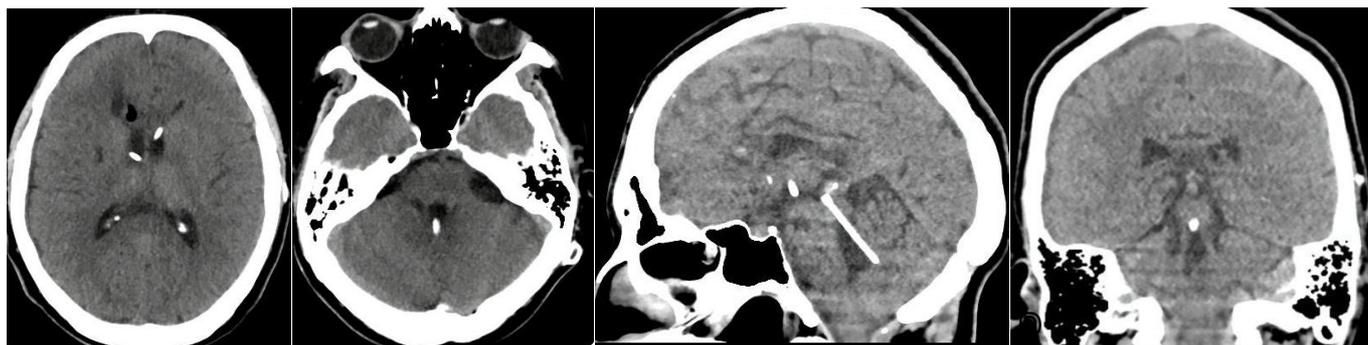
(A and B) Cerebral CT scan without contrast at 1 week after surgery, in axial section at the level of lateral ventricles and the IV ventricle showing a marked decrease in ventricular size. (C and D) Cerebral CT scan without contrast at 4 months after surgery, in sagittal section and in coronal section, showing collapse of the IV ventricle and lateral ventricle with a functioning VPS catheter and stent.
